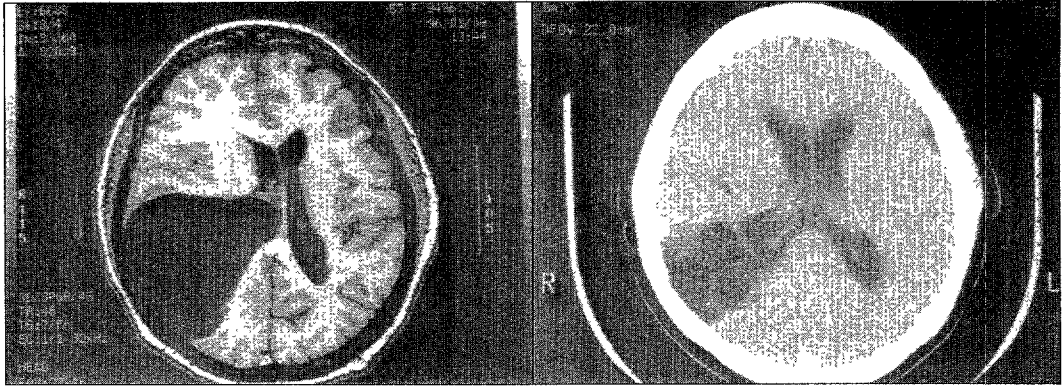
Case 3. Left : Axial T1-weighted magnetic resonance(MR) image revealing an arachnoid cyst in the middle cranial fossa with compression of lateral ventricle and midline shift. Right : Axial computerized tomographic (CT) image obtained 18 months after surgery demonstrating cyst reduction and disappearance of midline shift.
